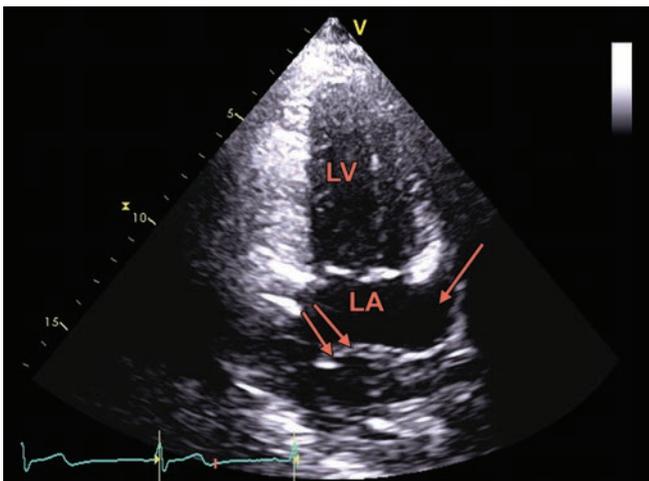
Apical 2-chamber viewing demonstrating the left atrial appendage (arrow) arising from the lower chamber. This helps differentiate CTS from supralvalvular mitral stenosis. Double arrow shows the membrane.
